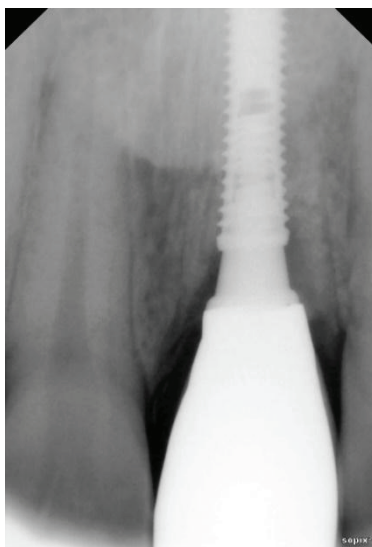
Post insertion periapical radiograph.
